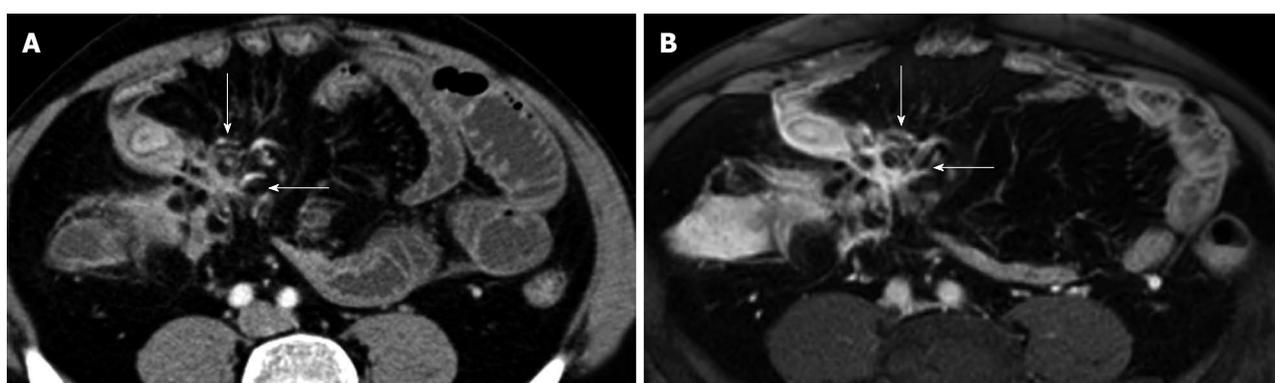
Transverse computed tomography (A) and post contrast T1-fat sat magnetic resonance imaging (B) images show a complex network between closely adherent small bowel loops appearing as a stellate configuration (arrows) due to entero-enteric fistulas.
